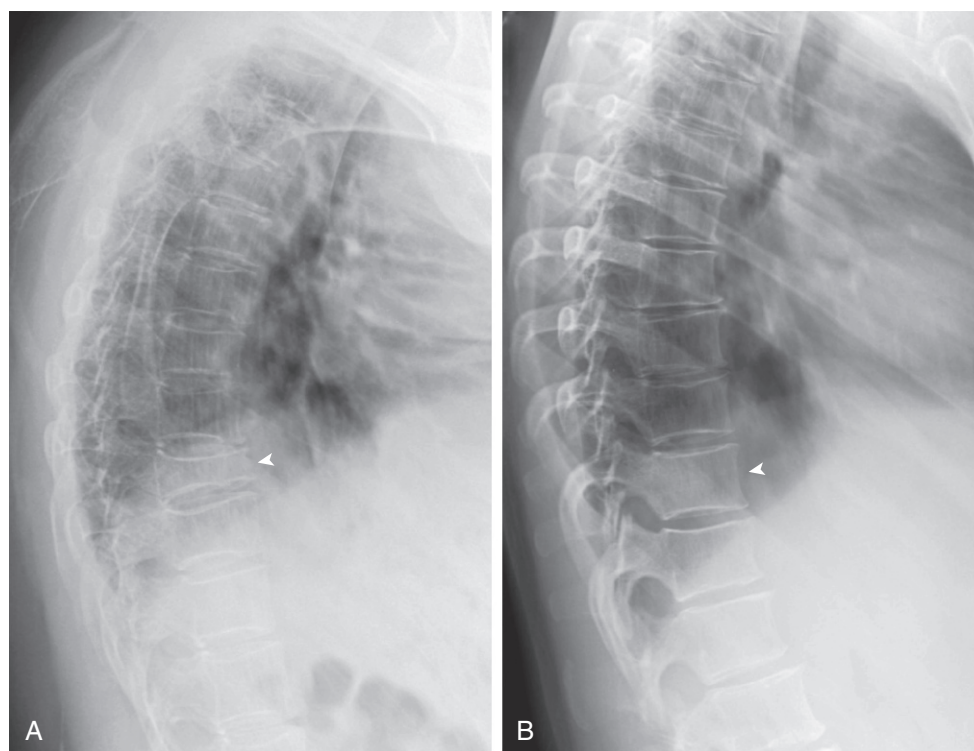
Estrogen treatment prevents osteoporosis. These lateral chest x-rays are from two 30-year-old women with Turner syndrome. Both had a karyotype of 45,X, both received growth hormone treatment for several years during childhood, and both were started on estrogen treatment at age 12 years. One patient stopped taking estrogen at age 18 years (A), and the other adhered to treatment (B). The woman who discontinued estrogen treatment experienced height loss, dorsal kyphosis, and chronic pain caused by collapse and wedging of vertebral bodies. The arrowhead points to T12 in each woman.
